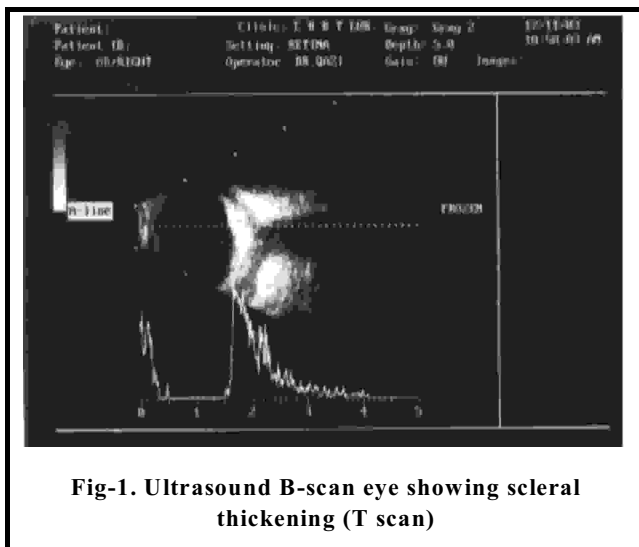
Ultrasound B-scan eye showing scleral thickening (T scan)
